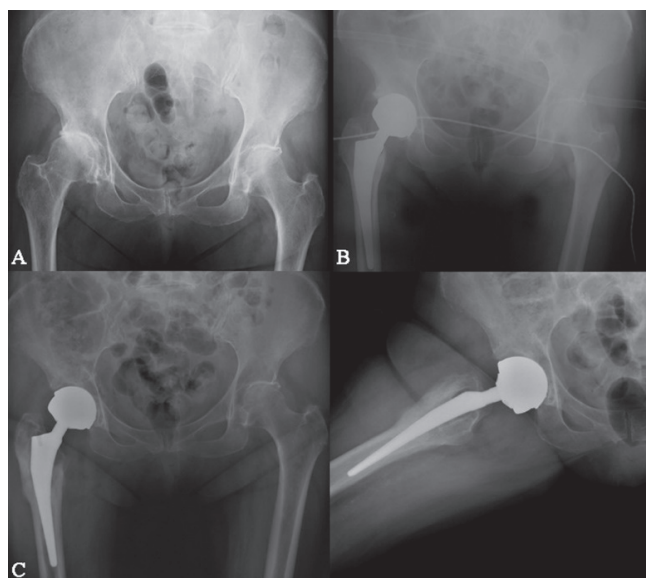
Right hip osteoarthritis. Preoperative x-ray (A), postoperative (B) and 10 years after surgery radiographs (C).
